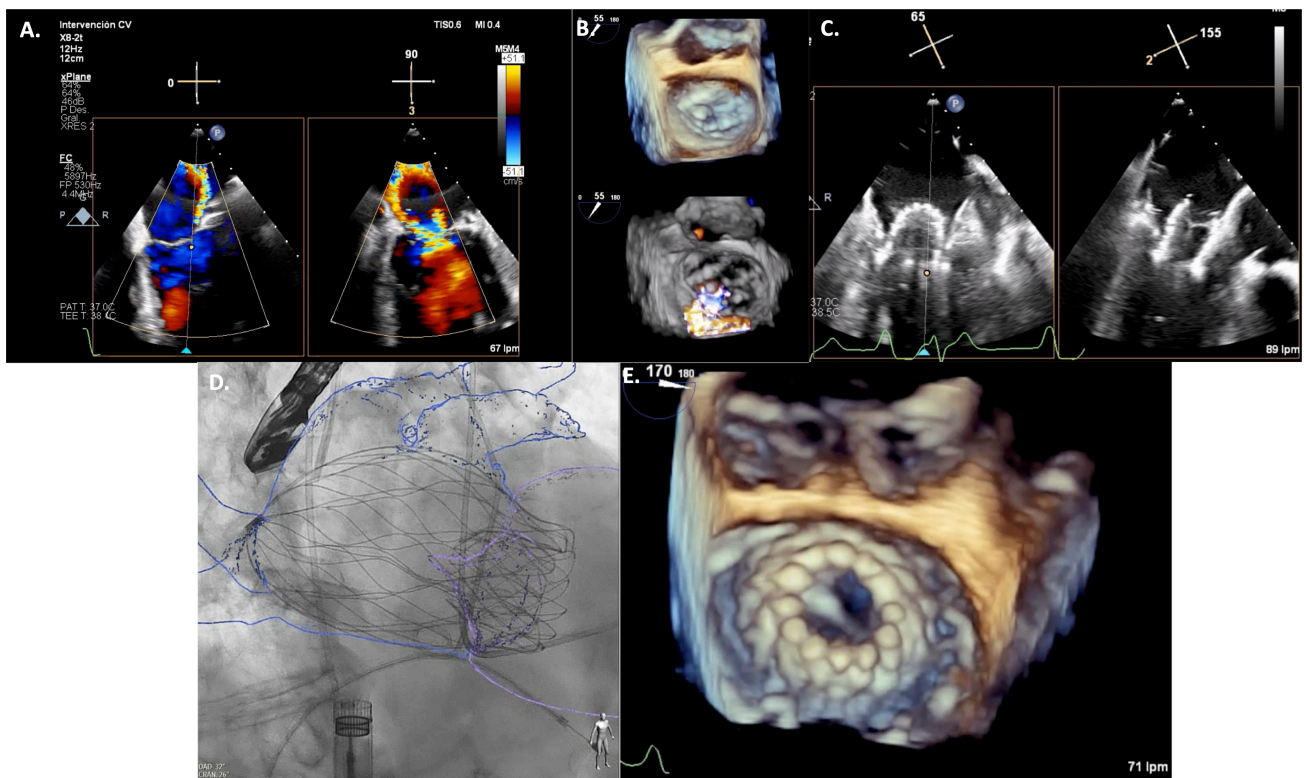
AltaValve implantation procedure. Transoesophageal echocardiogram showing baseline severe mitral regurgitation (MR) (A and B). Intraprocedural echocardiography guiding AltaValve implantation (C). Final fluoroscopic and echocardiography revealing adequate device positioning (D and E, respectively).
